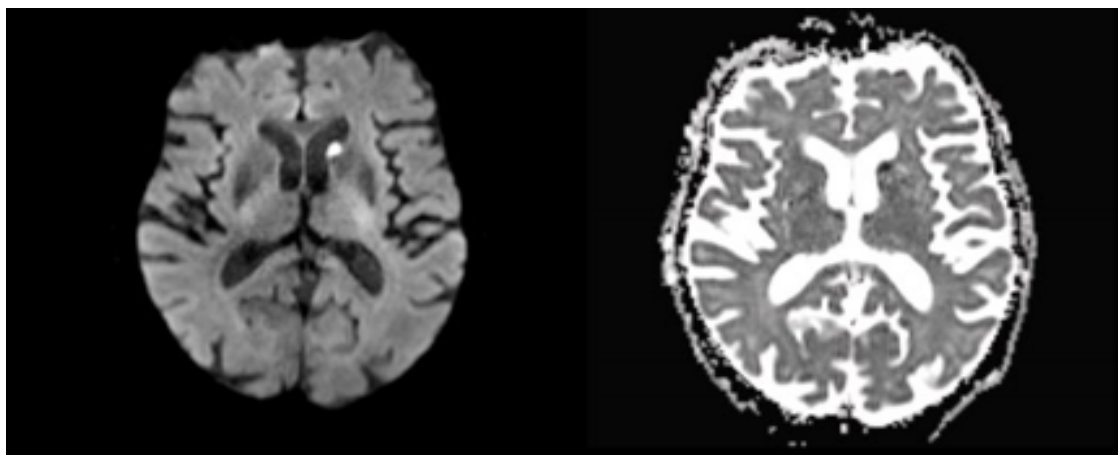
Diffusion-weighted MRI showed a lacunar ischemic lesion in the head of the left caudate nucleus (left side). Apparent Diffusion Coefficient showed a corresponding diffusion restriction (right side).
